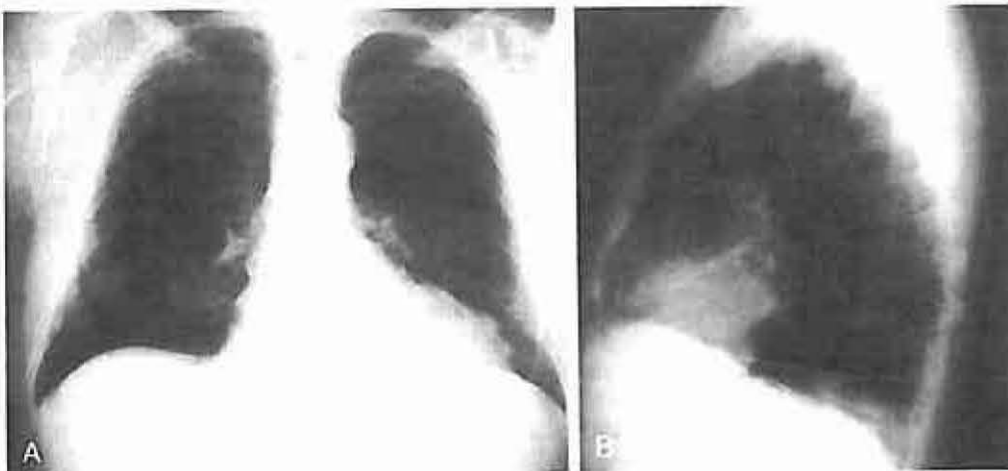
A, PA chest radiograph of 70-year-old retired insulator with calcified diaphragmatic pleural plaques and normal parenchyma (ILO 0/1). B, Lateral radiograph that better demonstrates calcified diaphragmatic plaques.
